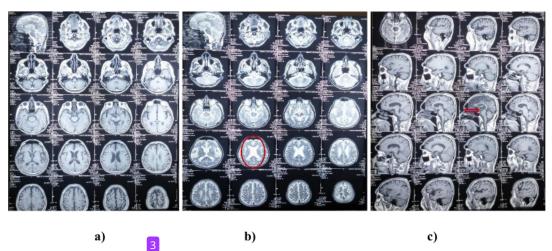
Non-contrast head MRI.a) Axial T1-weighted image (T1WI), b) Axial T2-weighted image (T2WI) showing white matter lesions in bilateral periventricular areas (circle). c) Sagittal T1-weighted image (T1WI) revealing "Humming bird" sign (arrow).
